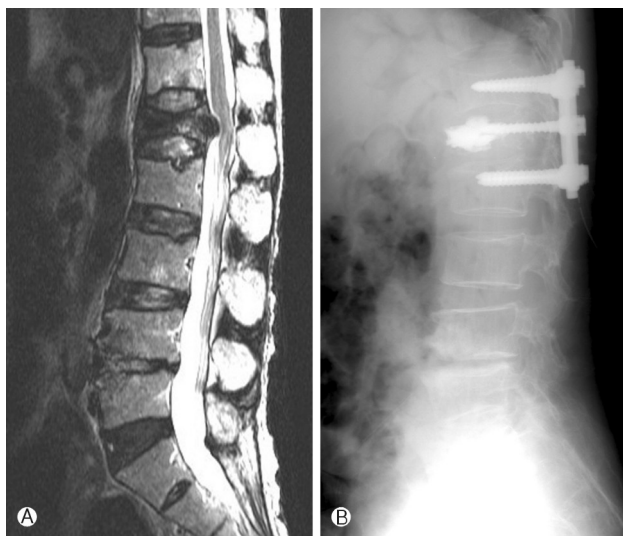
T2-weighted MRI showed cord compression by progressive compression fracture (A). Plain X-ray lateral image demonstrated decompressed and screw-fixed thoracolumbar spine (B).
